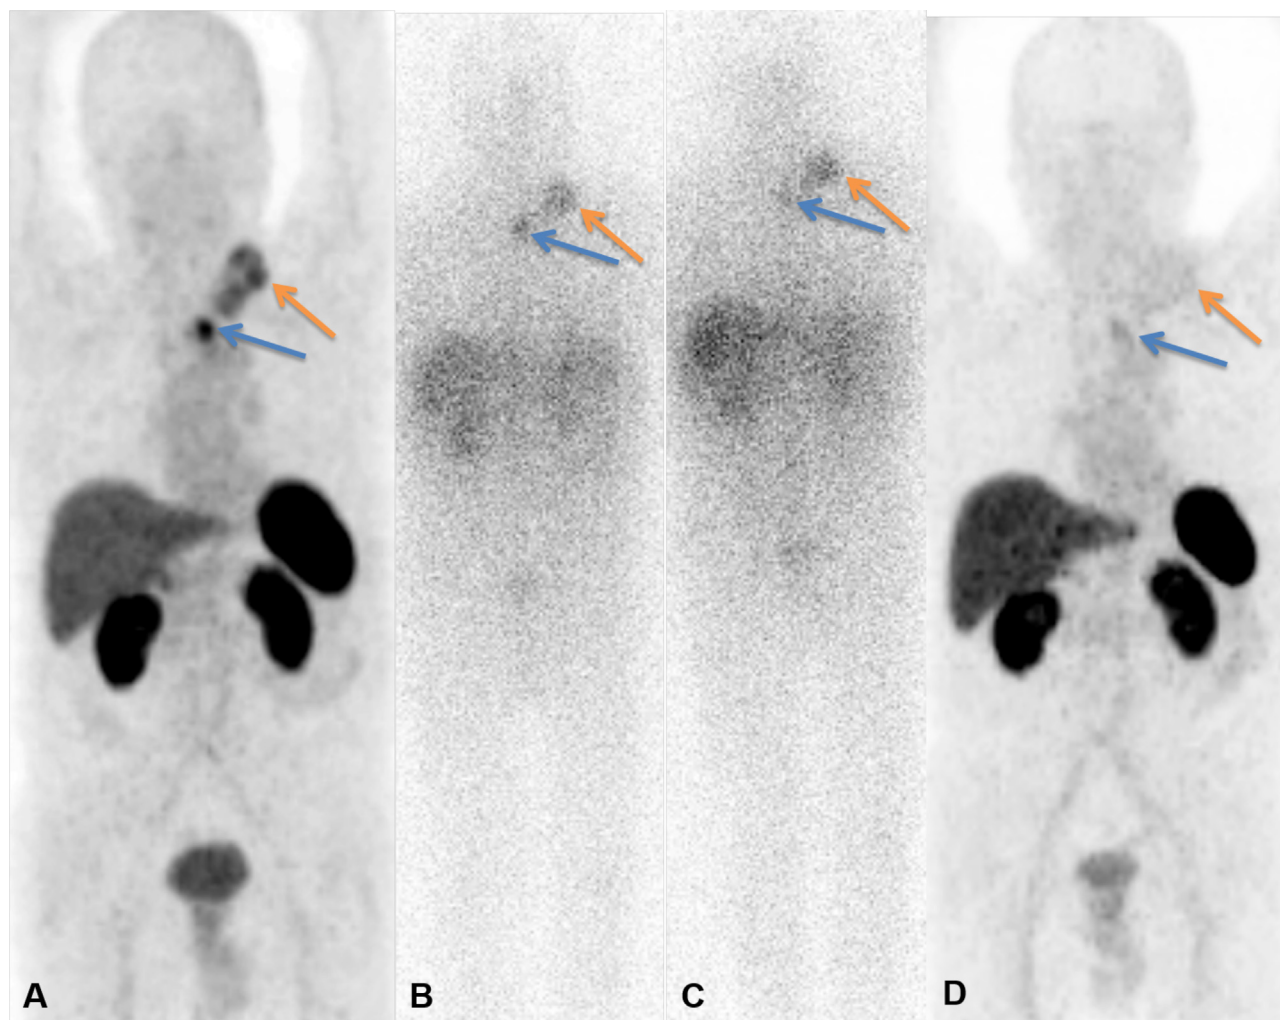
A 76-year-old male with recurrent sporadic medullary thyroid carcinoma involving the left lobe with infiltration of trachea and esophagus as well as supraclavicular and mediastinal lymph node metastases, s.p. complete thyroidectomy, recervicotomy, and sternotomy to operate the recurrence. The baseline ^{68}Ga -DOTANOC PET/CT demonstrated significant SSTR expression (A) in the extensive left supraclavicular lymph node mass (orange arrow) and the retrotracheal lymph node (blue arrow). The patient was treated with two cycles of PRRT using ^{90}Y -DOTATATE. The posttherapy whole-body Bremsstrahlung scans (B—first cycle, C—second cycle) demonstrated corresponding high uptake at the two sites. The follow-up ^{68}Ga -DOTANOC PET/CT (D) revealed partial remission of the disease after two cycles of PRRT.
